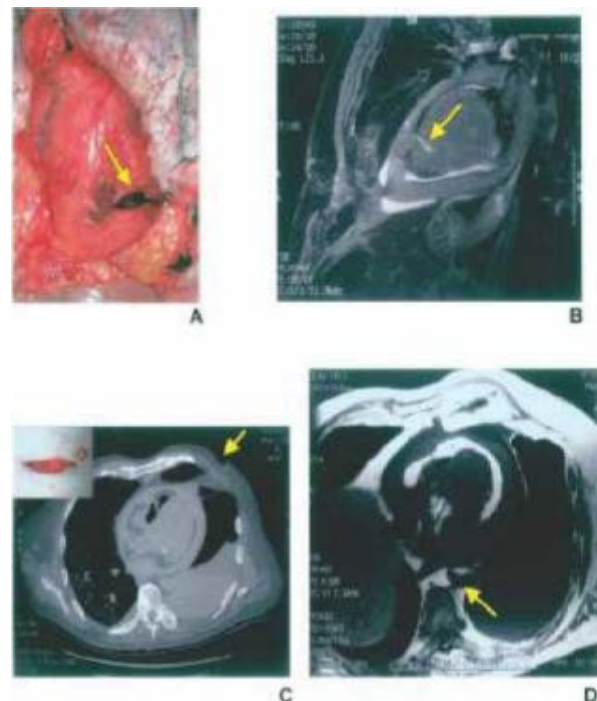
Patient who died from a stab wound located in the thoracic region. (a) Autopsy image; (b) MRI coronal section; (c) computed tomography and magnetic resonance imaging; (d) MRI axial section.
